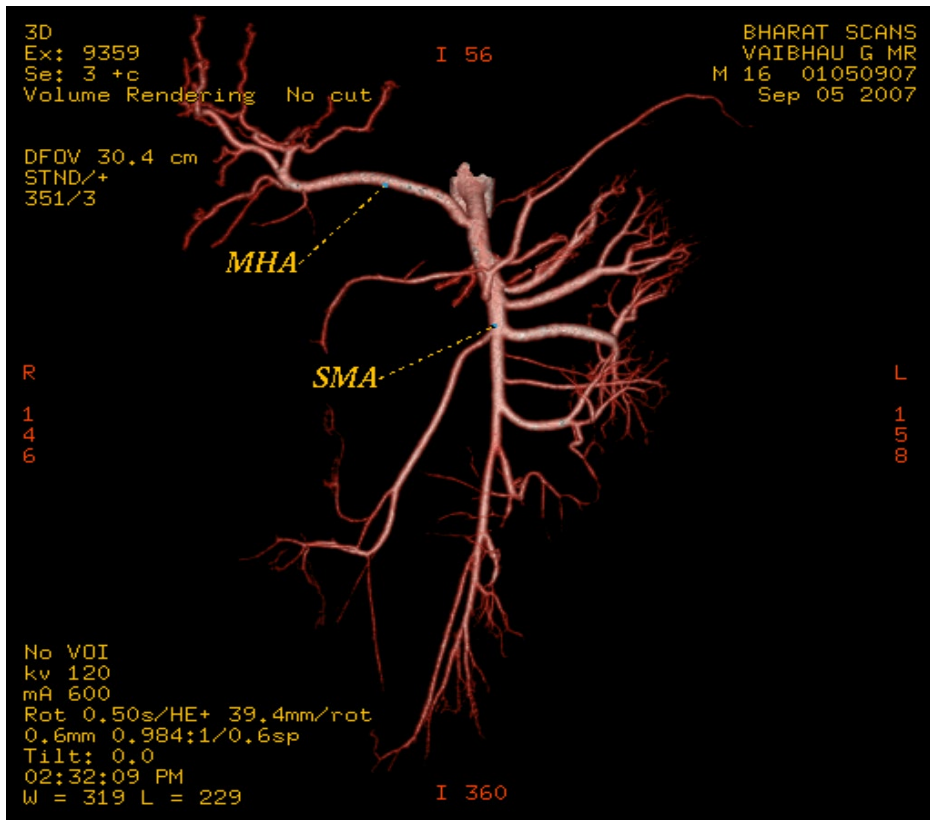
(CT Angiogram) SMA and Hepatic artery as a common trunk
